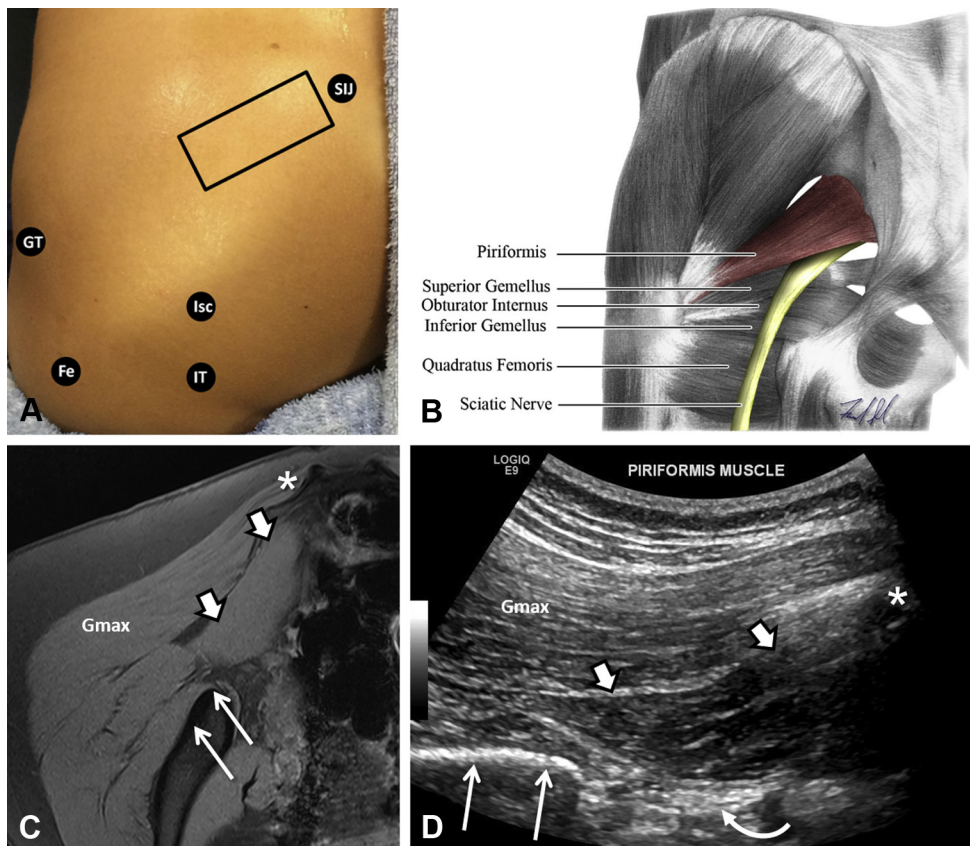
Topographical orientation for US transducer placement to image the deep external rotator muscles. (A) Bony landmarks of the sacroiliac joint (SIJ), greater trochanter (GT), ischium (Isc), posterior femur (Fe), and ischial tuberosity (IT) are highlighted with black circles. The solid black rectangle represents the orientation of the US transducer to image the piriformis muscle in long axis as it emerges from the greater sciatic foramen. Anatomical plate (B) demonstrates the gross anatomy of the deep external rotator muscles and sciatic nerve. Transverse MRI (C) and US (D): The piriformis muscle (short arrows) is visible in long axis anterior to the gluteus maximus muscle (Gmax) as it emerges from the anterior sacrum (asterisk) and courses posterior to the ilium (long arrows). The sciatic nerve (curved arrow) is visible on the US image as an ovoid hyperechoic structure deep to the piriformis muscle. US = ultrasound; MRI = magnetic resonance imaging.
